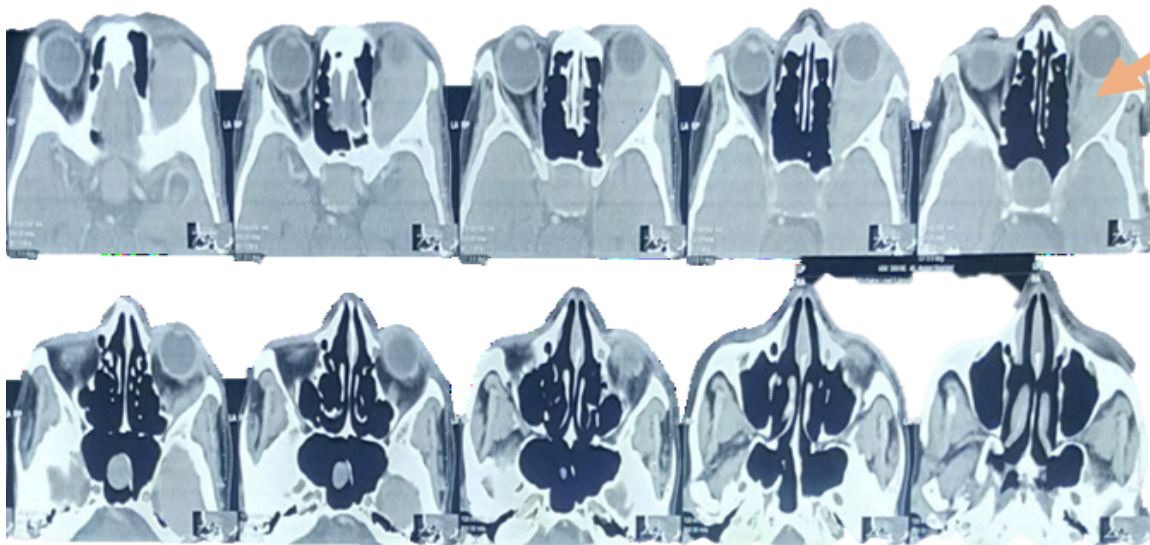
Contrast-enhanced CT Axial scan head, showing a mass in the left orbit (arrow)
